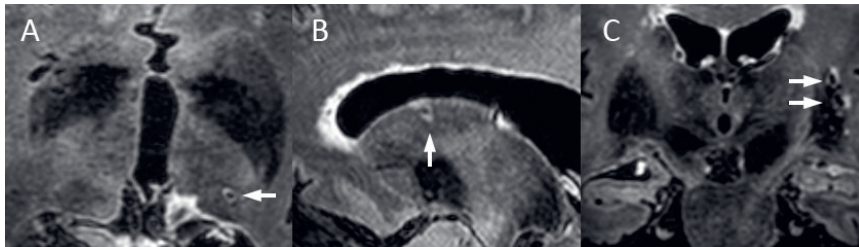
Examples of microinfarcts in the deep gray matter on 7T MRI. A: Microinfarct with a diameter of 2.3 mm (arrow) in the left thalamus of a 73-year old female on transversal 7T FLAIR. B: Microinfarct with a diameter of 2.9 mm (arrow) in the left caudate nucleus of a 64-year old male on sagittal 7T FLAIR. C: Two microinfarcts with diameters of 3.0 mm and 3.2 mm (arrows) in the left putamen of a 65-year old male on coronal 7T FLAIR. Note that the gliotic rim extends into the adjacent external capsule.
